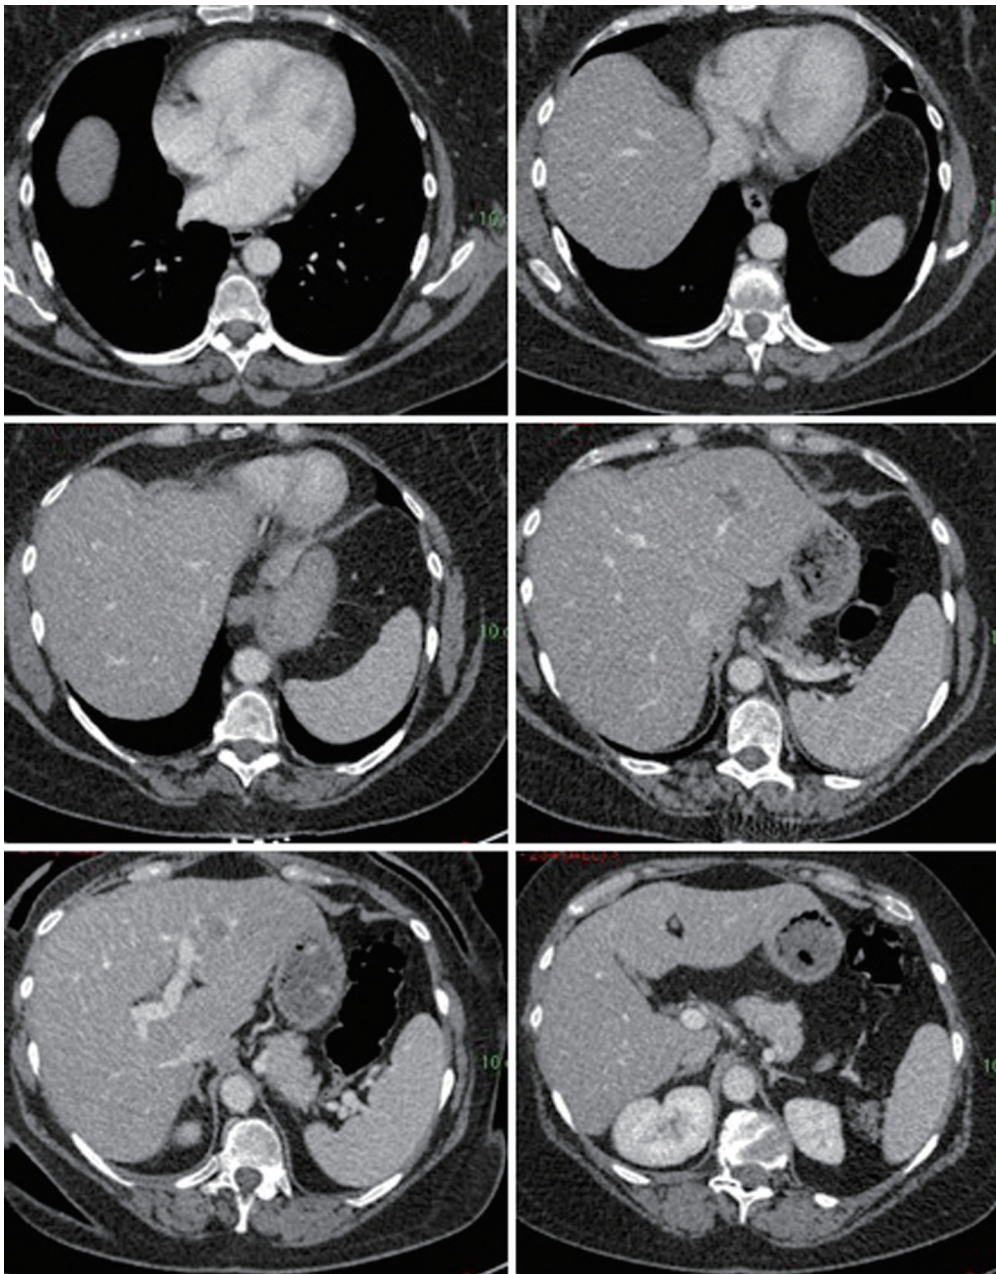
Preoperative triple phase CT liver in patient 1.
